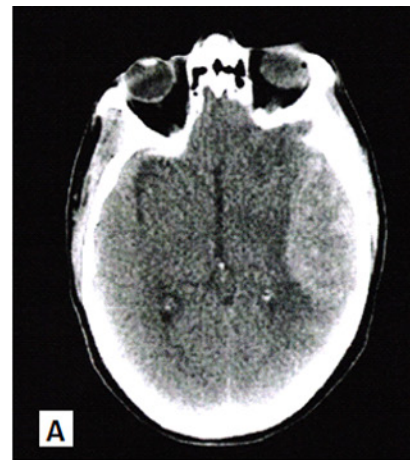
Cranial images of the patient: Transaxial CT (A), Transaxial SPECT (B), Transaxial SPECT/CT (C) fusion images show increased ^{99m}Tc -MDP uptake in the heterogeneous area of the brain parenchyma in the area matching the left frontotemporal region (Gaziantep University Faculty of Medicine, Department of Nuclear Medicine)
